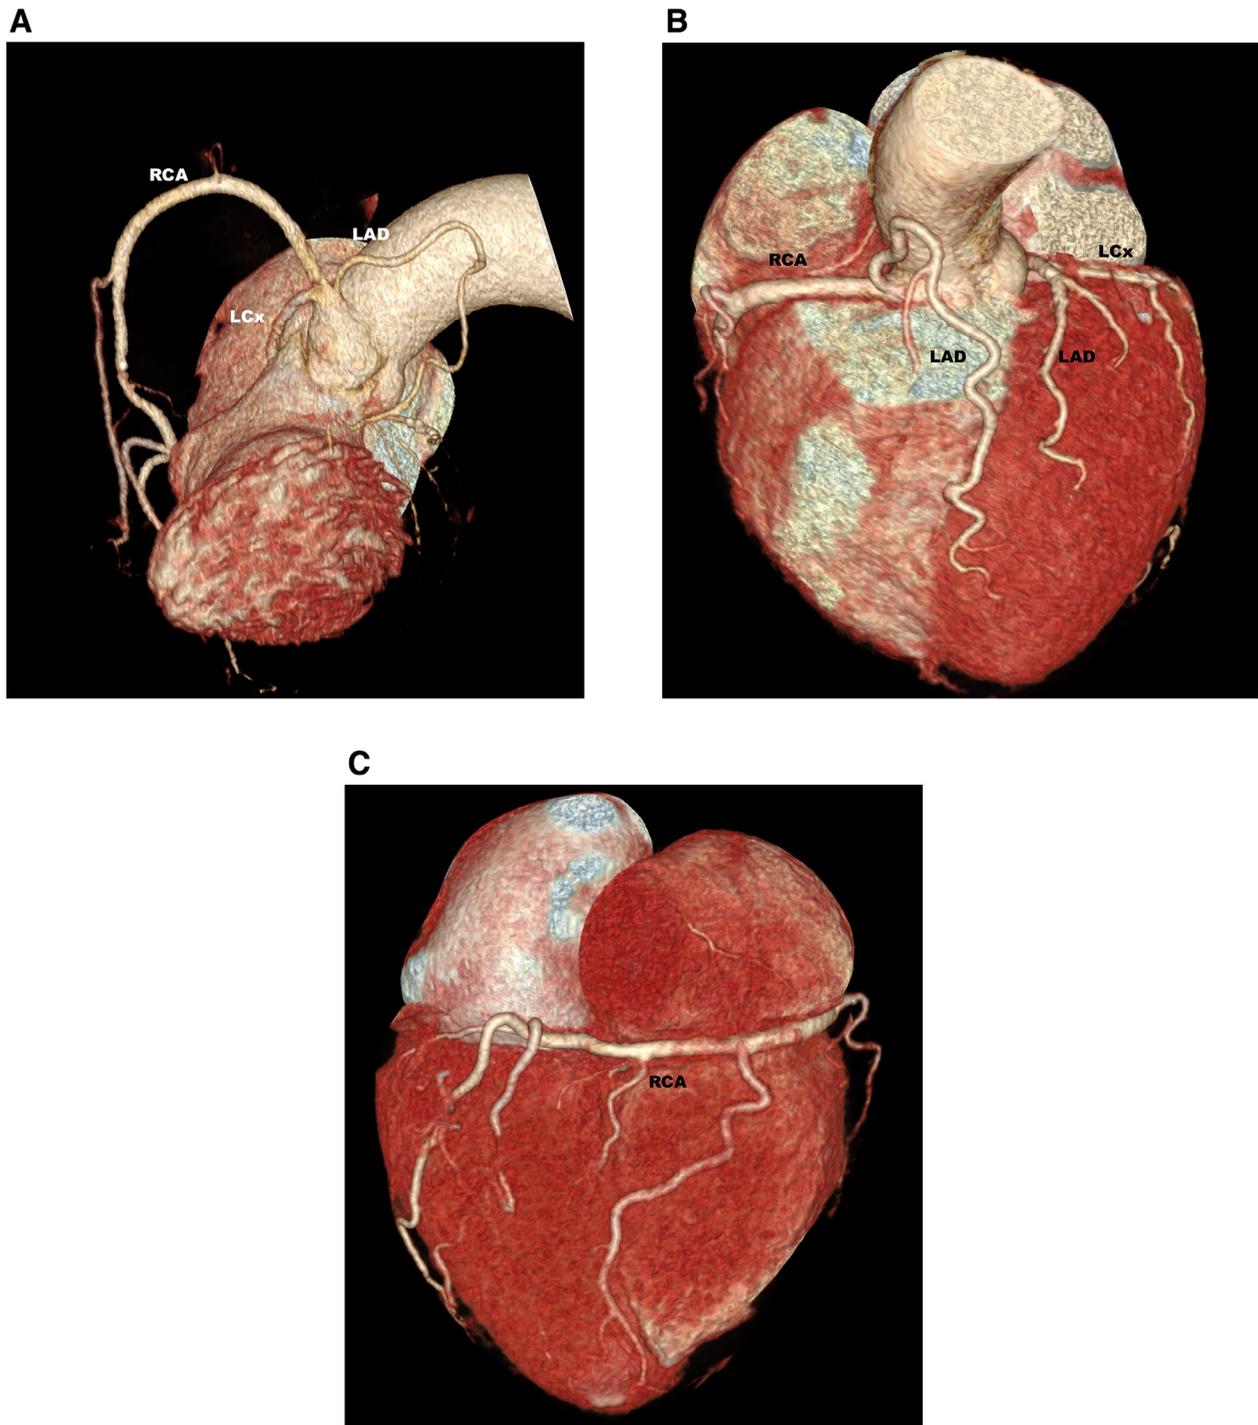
Single coronary artery type Lipton type R3. (A to C) Coronary computed tomography angiography, volume-rendered reconstructions, oblique, anterior and posterior views, respectively. LAD = left anterior descending artery; LCx = left circumflex artery; RCA = right coronary artery.
